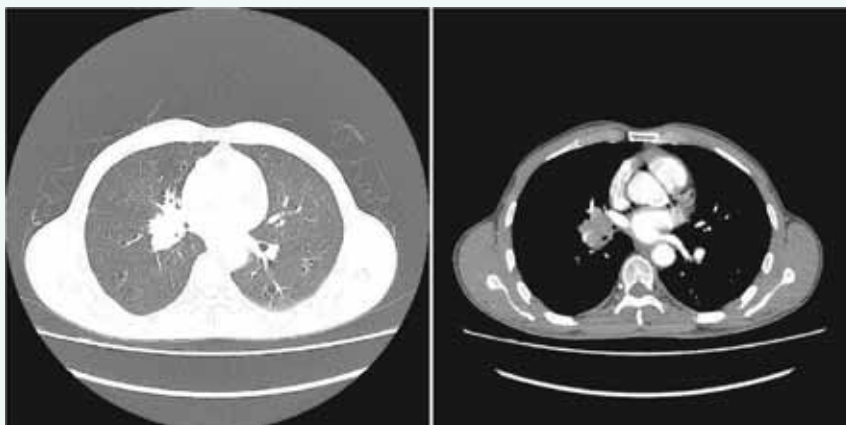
Chest CT plain scan + enhancement on July 14, 2023. Large right hilar shadow with a soft tissue mass, unclear boundaries and surrounding adjacent blood vessels, with a size of approximately 3.1*2.5 cm and a CT value of approximately 39 HU.
